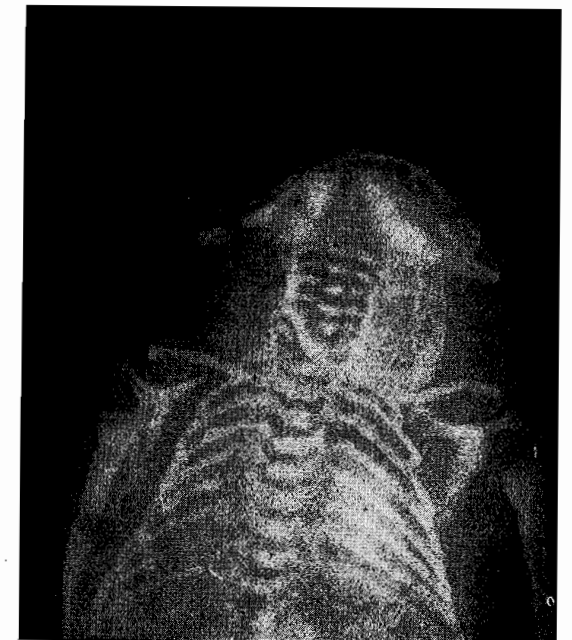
Direct X-ray visualization of an anencephalic stillborn monster after delivery, showing the marked distortion of the bony contour of the head and the absence of the cranial vault.
